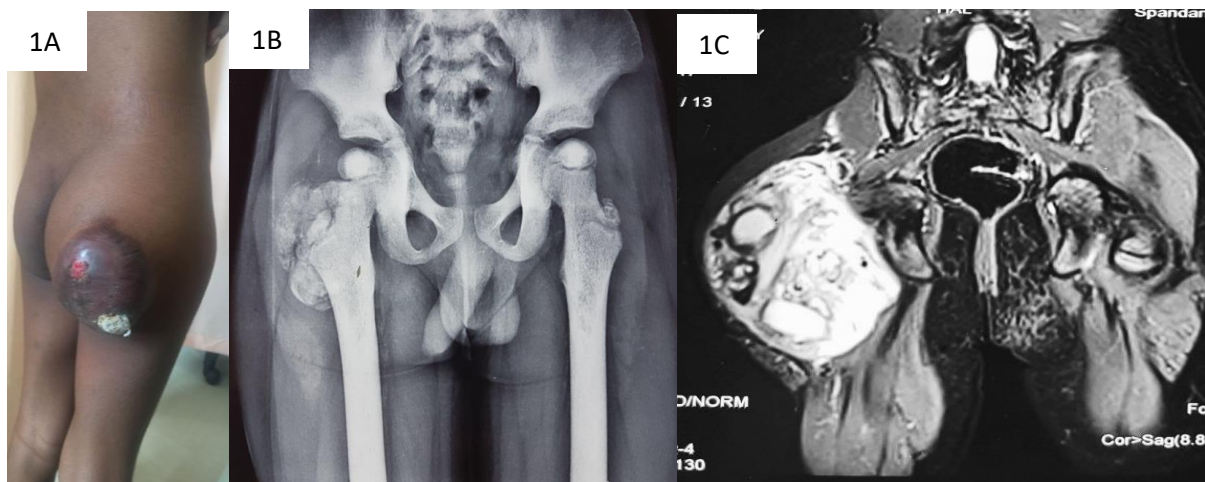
Clinical photograph showing large right gluteal swelling; 1B: X ray showing flocculent heterogenous calcific shadows around neck and greater trochanter of right femur; 1C: MRI pelvis showing hyper-intense, multi-locular cystic lesion in soft tissue of right gluteal region with characteristic "Sedimentation sign" present. Underlying bone appears normal.
